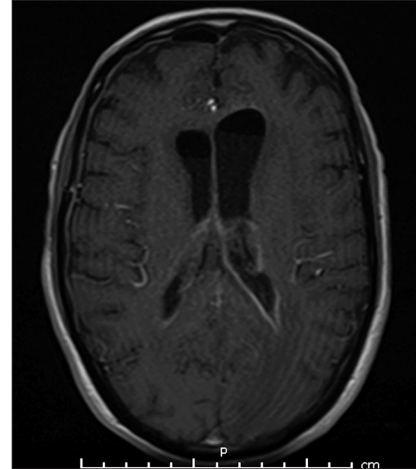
Magnetic resonance imaging of the brain following IRRFlow® treatment showing decreased ventricular abscess burden.
